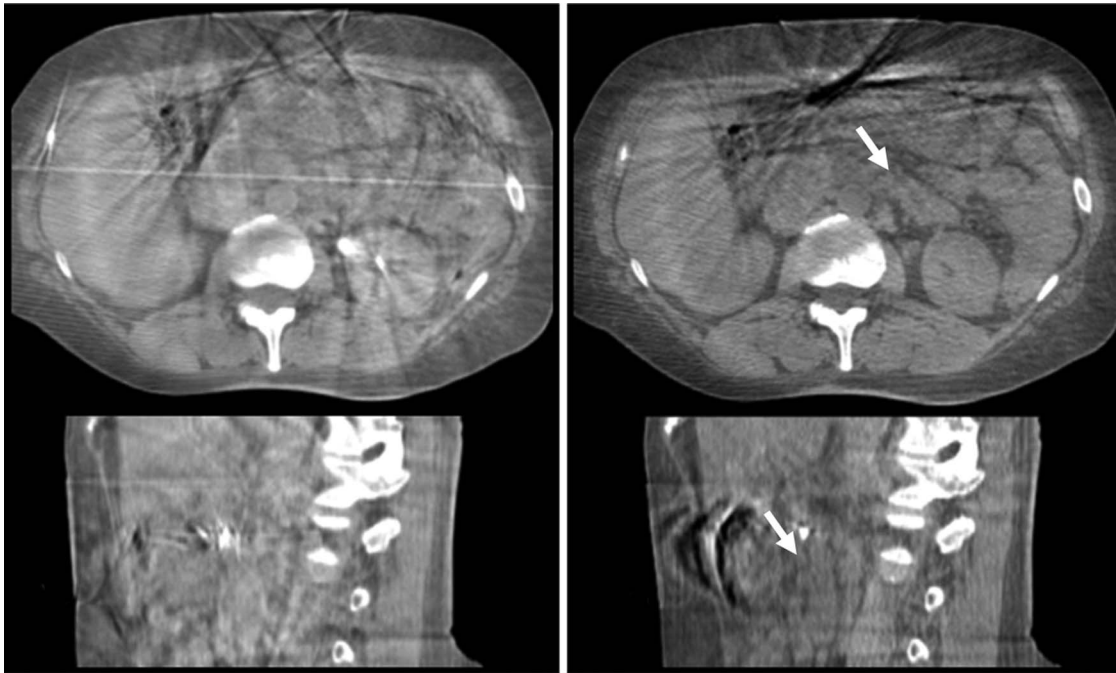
Transaxial and sagittal CBCT images of a free-breathing patient treated for pancreatic cancer. Image planes intersect in the pancreas, inferior to the fiducial. Left column is standard CBCT, right is gated CBCT. Arrows indicate pancreas in the gated CBCT.
